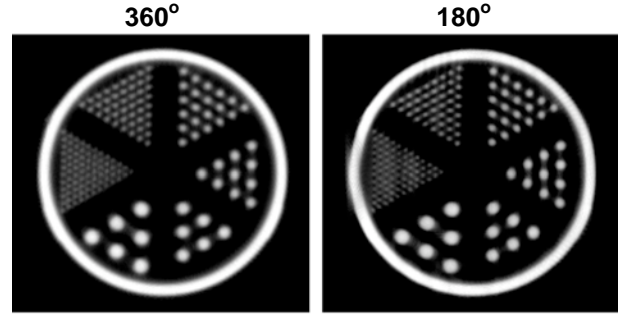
OSTR iteratively reconstructed CT cold rod data acquired with the central cone-beam ray aligned with the COR. (LEFT) 360° of projection data. (RIGHT) 180° of projection data. Three slices were summed to create these images.
